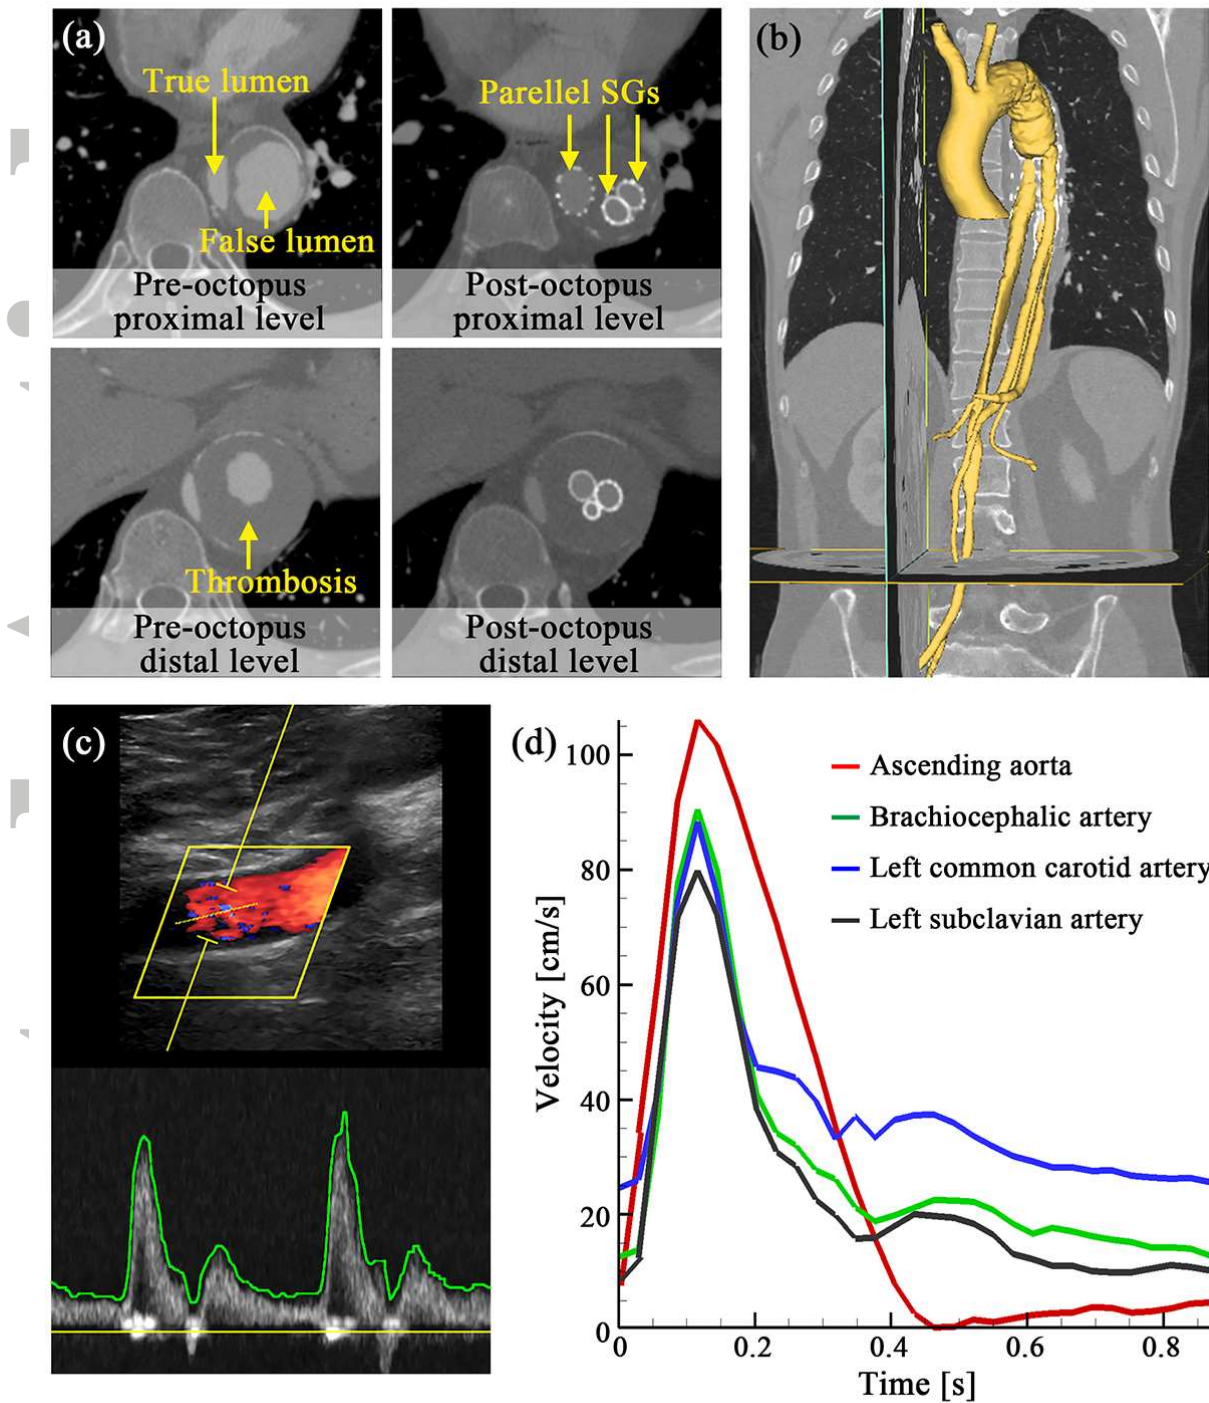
(a) shows the representative slices of CTA datasets; (b) displays the 3-D reconstructed aortic model; (c) shows the Doppler ultrasound velocimetry; and (d) is the extracted velocity data as the velocity boundary conditions for the computational models.
